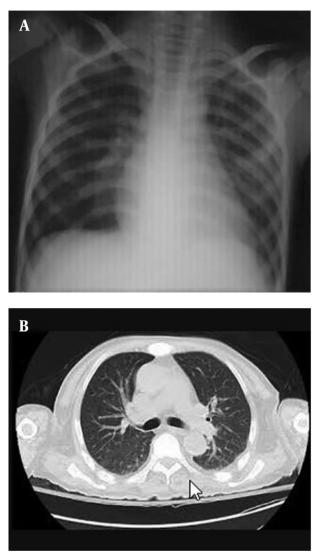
A and B, Four days after starting dexamethasone, chest c-ray and CT showed disappearance of the lung infiltrations
